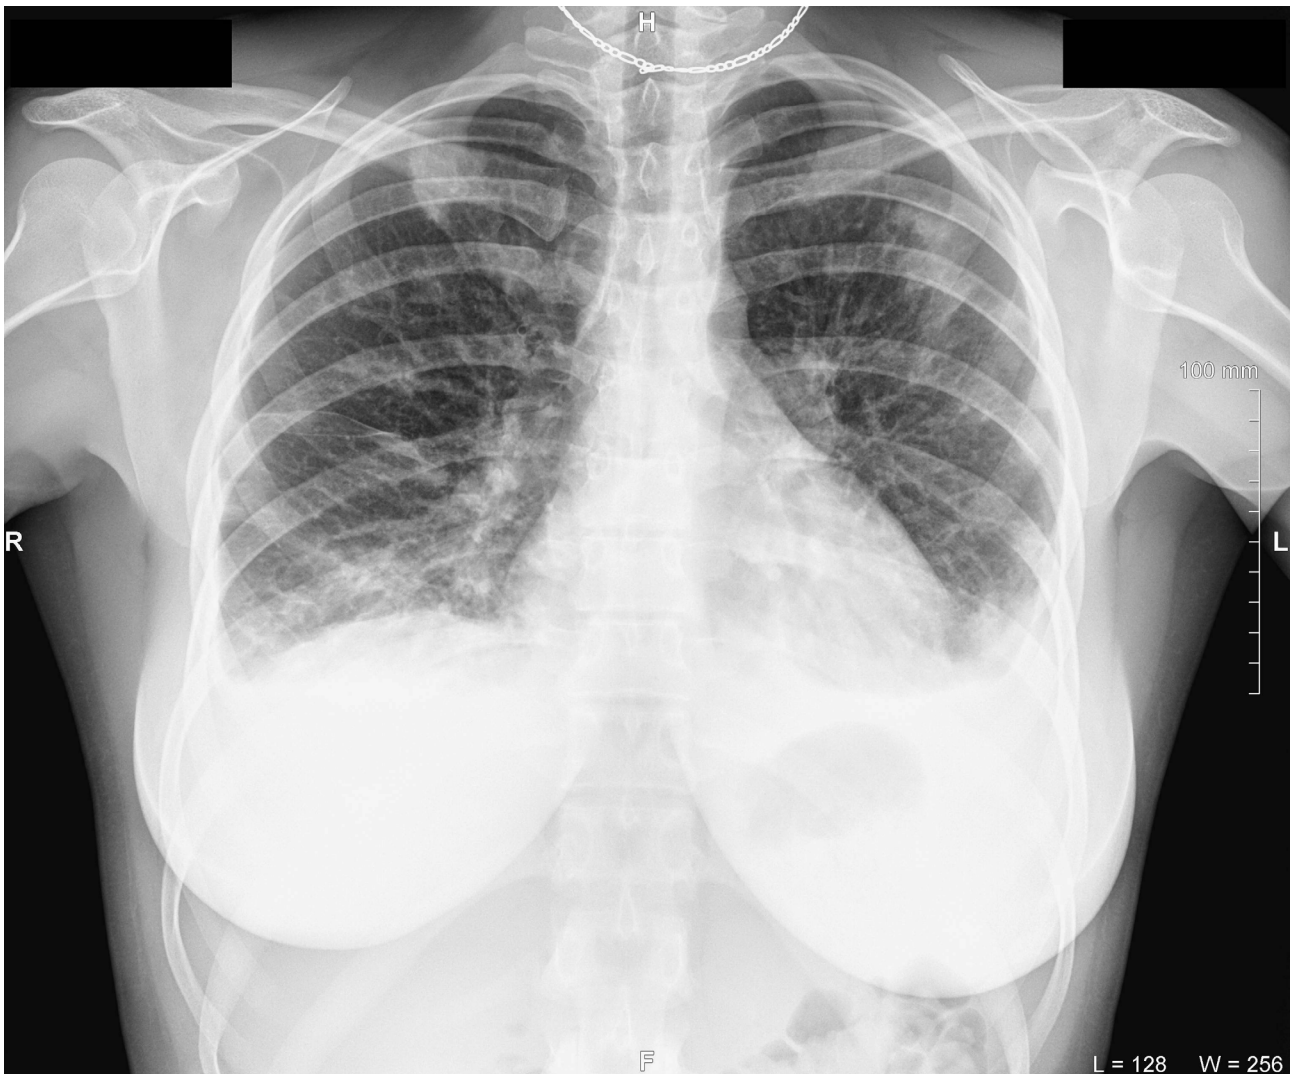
Antero-posterior view of chest X-ray on hospital day 7. Radiological data corresponds to the bilateral multilobar pneumonia and pleurisy. H, head; R, right; L, left. Printed with permission and copyrights retained by I.I.F.
